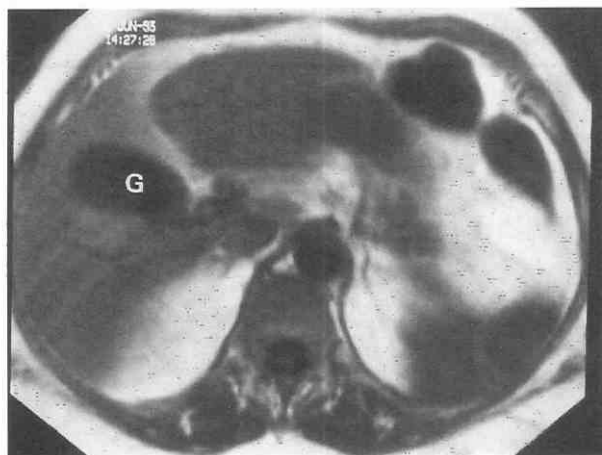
Normal appearance of gallbladder on short TR (T1-weighted) image. Note hypointense signal of gallbladder (G). TR = 700; TE = 10.
